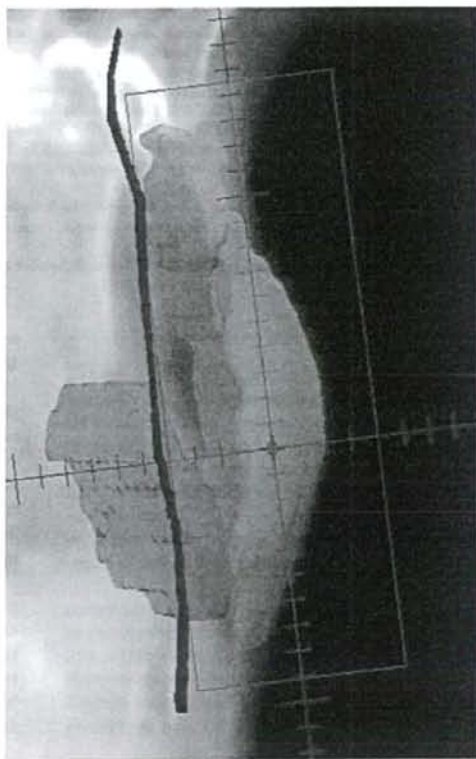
Digitally reconstructed radiograph for a typical modified tangential irradiation technique. Breast planning target volume is shown in pink, axillary nodal planning target volume in green, the heart in red, and the midsternal line in blue.
